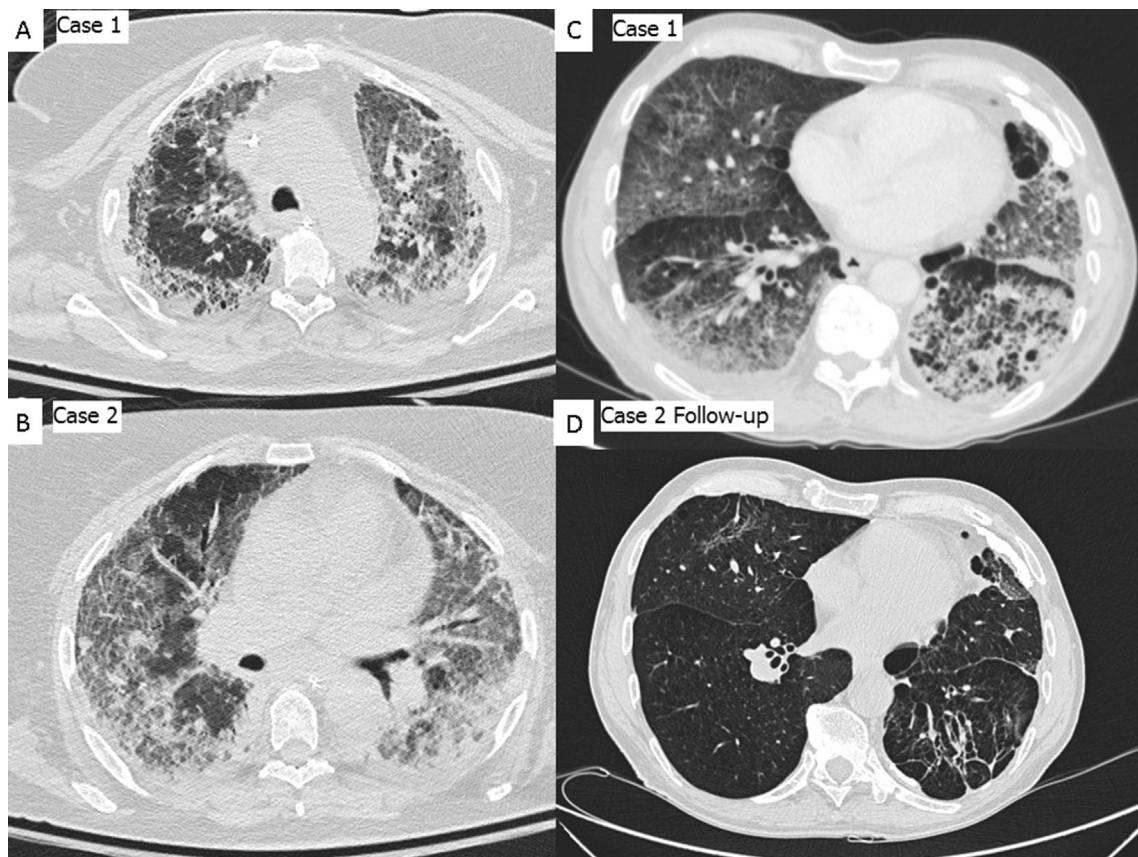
A and B. CASE 1. Computed tomography upper and lower image. Mosaic perfusion pattern is seen in the upper areas of the lung (a). Diffuse areas with ground glass appearance, especially in the peripheral part of the lungs is evident. Thickening of the intra and interlobular septae and traction bronchiectases is seen, which was the main reason for suggesting ILD. Several consolidated areas mostly localized subpleural may represent abscesses or infarctions. In the spared parenchyma emphysematous changes appeared, and changes mimicking honeycombing probably represent paraseptal emphysema. C. CASE 2. Computed tomography. Emphysema can be seen in the spared lung parenchyma. Furthermore, large consolidated areas and peribronchial thickening is present. Bronchiectasis most evident in the left lower lobe probably was interpreted as honeycombing. D. CASE 2 FOLLOW-UP. At follow-up HRCT showed extensive emphysema. Bronchiectasis in the left lower lobe is evident.
